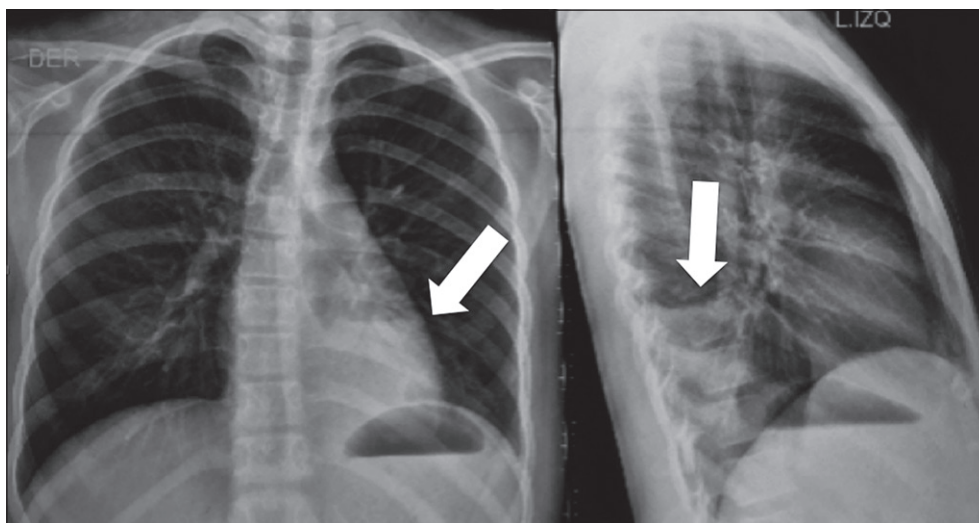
Chest X-ray shows image of pulmonary condensation in the left lower lobe (arrows)
